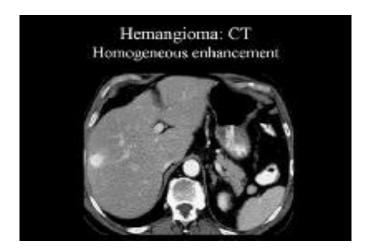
Contrast-enhanced computed tomography (CT) scan that was obtained during the arterial-dominant phase. This image demonstrates a hemangioma with homogeneous and intense contrast enhancement.
